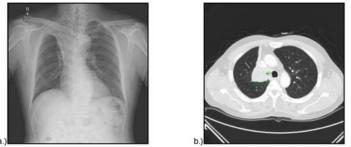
(a) Chest X-ray:: the right upper lobe bronchus obstruction due to cancer as atelectasis is observed, [6th. Jan. 2010]. (b) Chest CT: right upper lobe bronchus and bronchial cancer is proven in the right upper lobe atelectasis, [7th. Jan. 2010]
